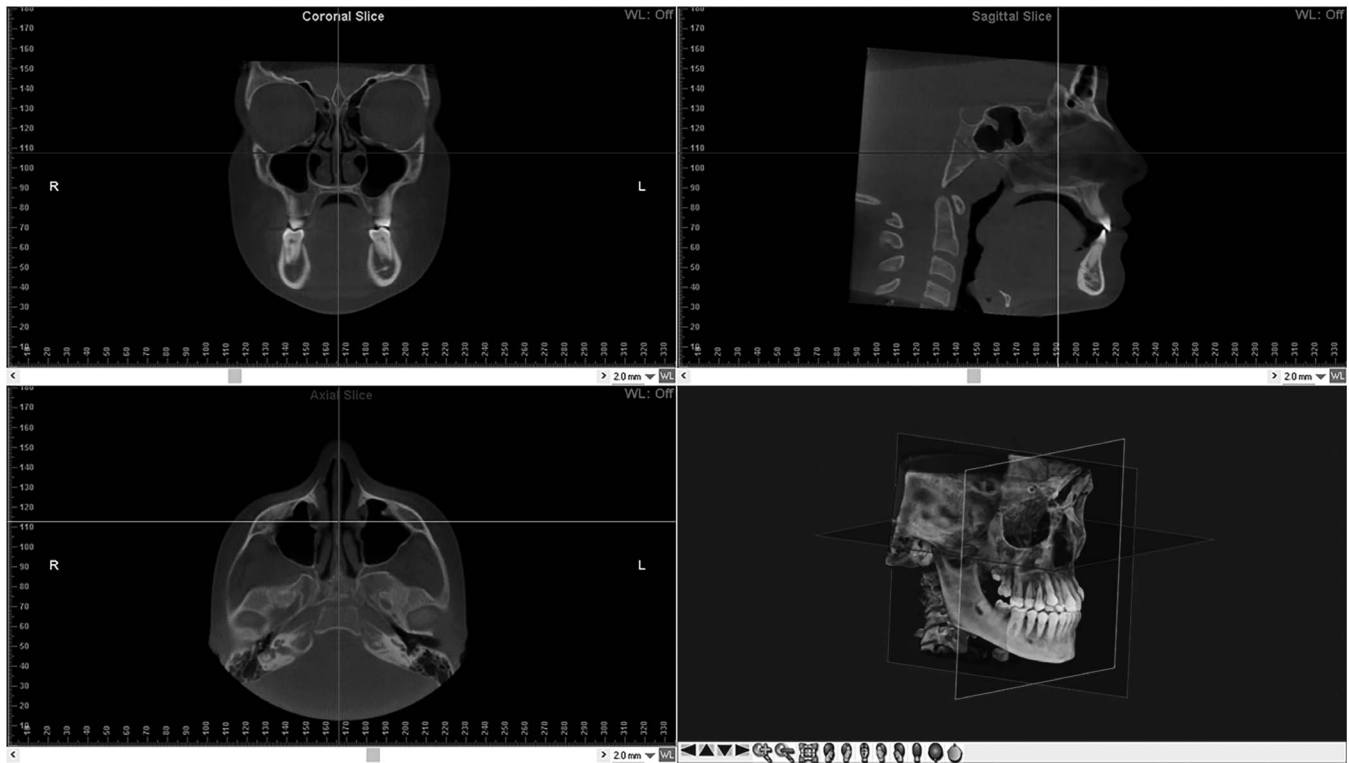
Head reorientation in the axial, sagittal and coronal planes of CBCT scans. The 3D image shows the head orientation in 3D space. Lines represent the reference axes. CBCT indicates cone-beam computed tomography; 3D, three-dimensional.
